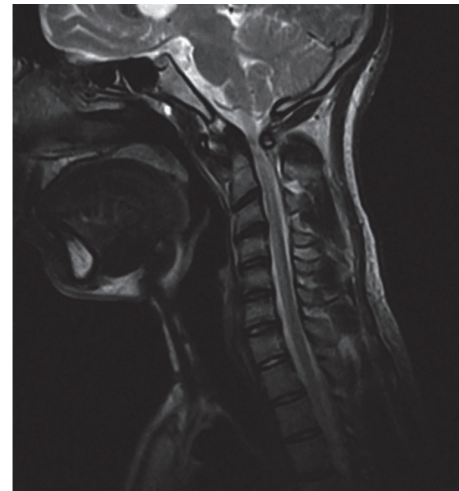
MRI T2 Revealed Evidence of C1-C2 Subluxation and Narrowing of the Spinal Cord Canal
